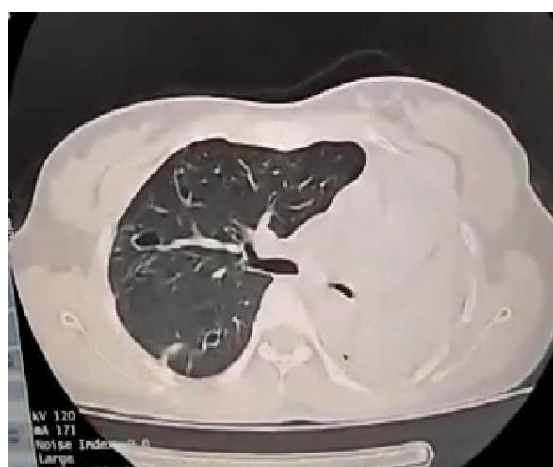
CT chest axial view showing narrowed left main bronchus with left lung collapse.
